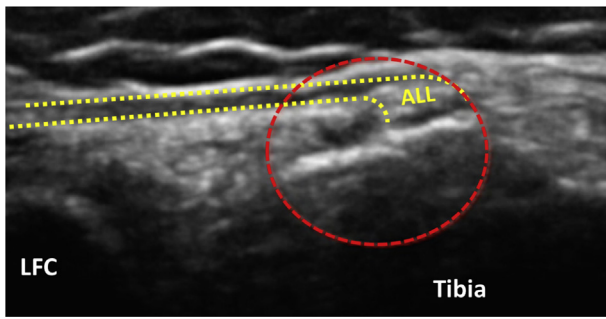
Ultrasound image of a right knee with an anterolateral ligament (ALL) injury at its tibial insertion. There is cortical damage (red circle), but the bone fragment is not detached. This appears to be bony avulsion. (LFC, lateral femoral condyle.)
